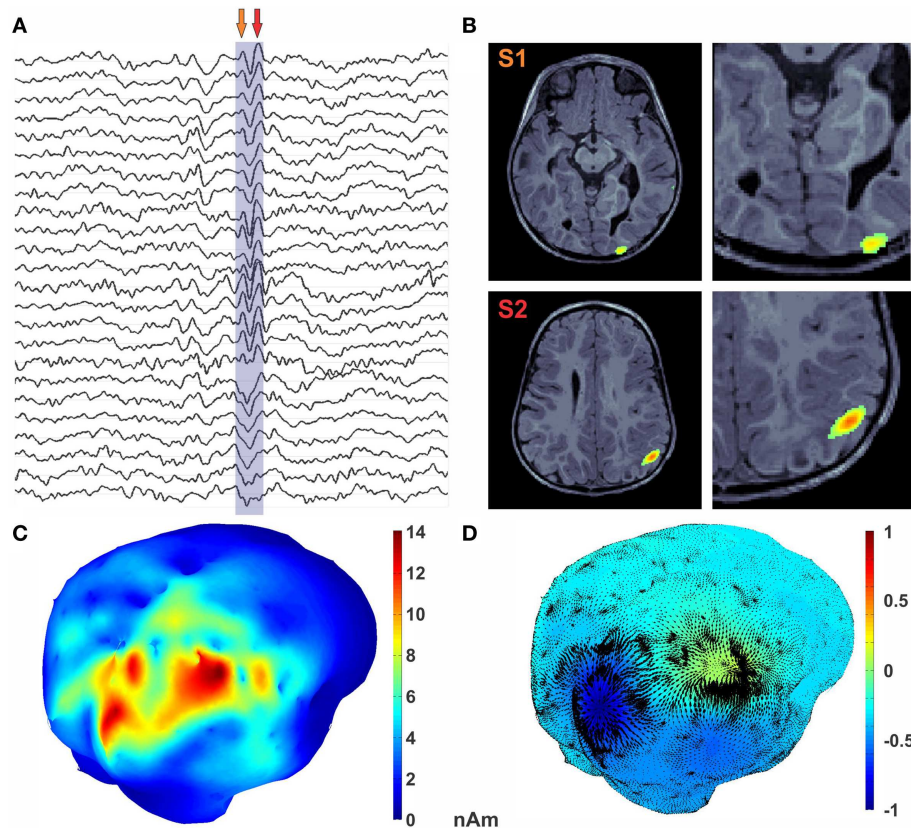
Encoding of epileptic spike in diverging features. (A) MEG traces with epileptic spike marked. (B) MRI with MEG activity represented as the color texture. (C) Average MEG activity during the spike. (D) U HHD scalar potential is mapped onto the cortical surface
